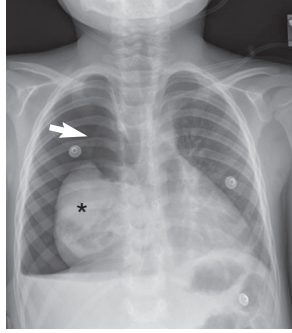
Chest radiograph of a 5-year-old boy with a right-sided pneumothorax caused by necrotizing pneumonia. There is a large volume of free air in the right pleural space (*arrow*), and the right lung is deflated and collapsed (*asterisk*). The right hemidiaphragm is flattened, and the pneumothorax can be seen extending into the left chest. A chest tube has not yet been inserted.
